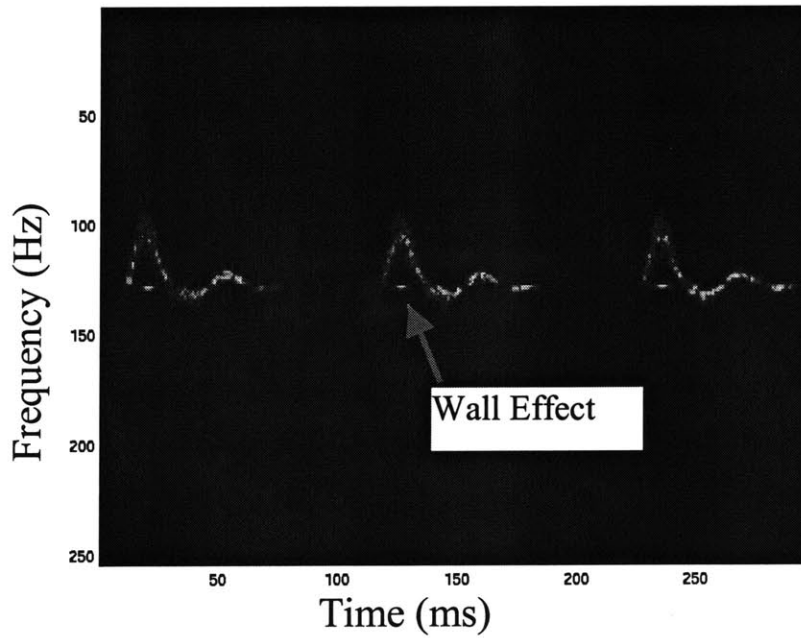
Wall velocity effect (Doppler frequency)
